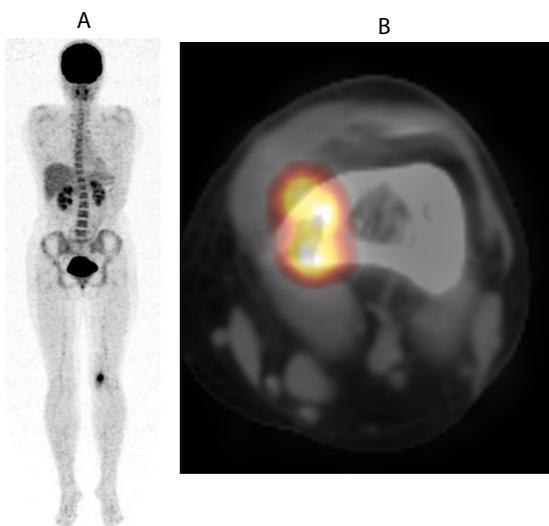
An anterior (A) and an axial (B) view of 18F-FDG PET/CT images reveal an increased uptake of the distal aspect of the left femur (SUVmas 6.6).
